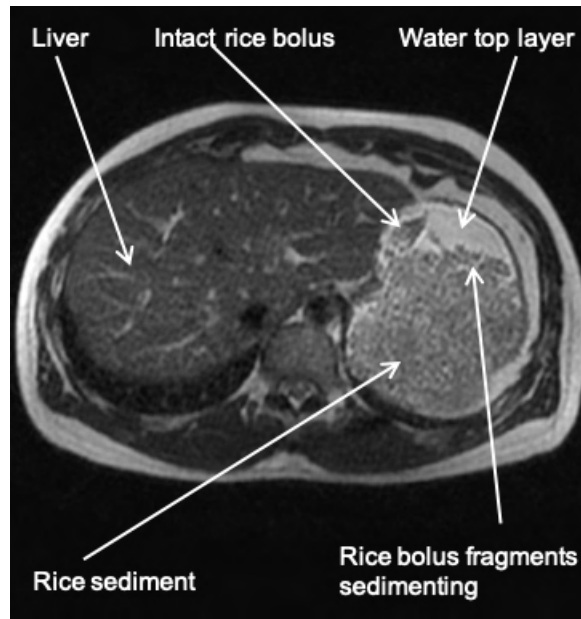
MRI image of rice bolus in the stomach.
